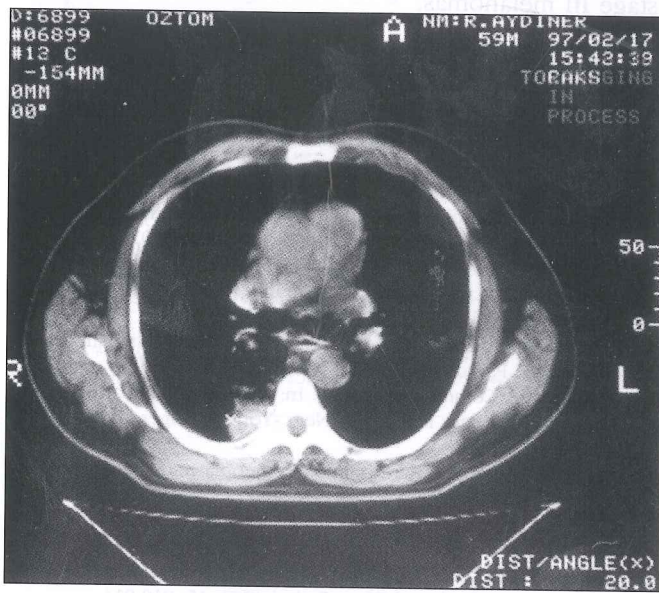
Chest CT scan at the level of main stem bronchial origins demonstrating tumor.
